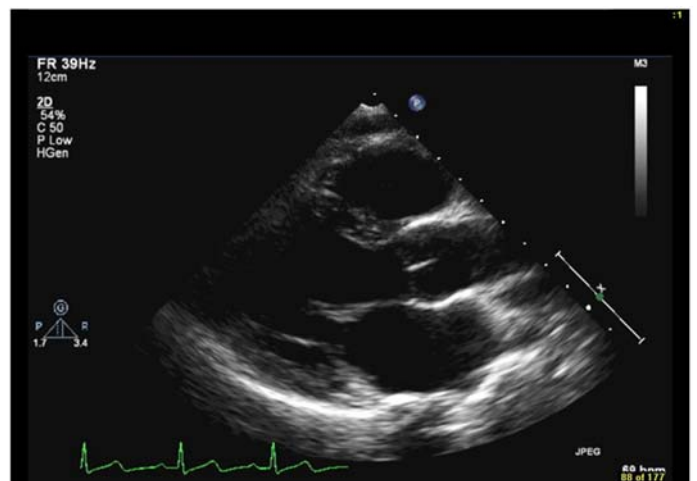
Parasternal long axis (PLAX)
